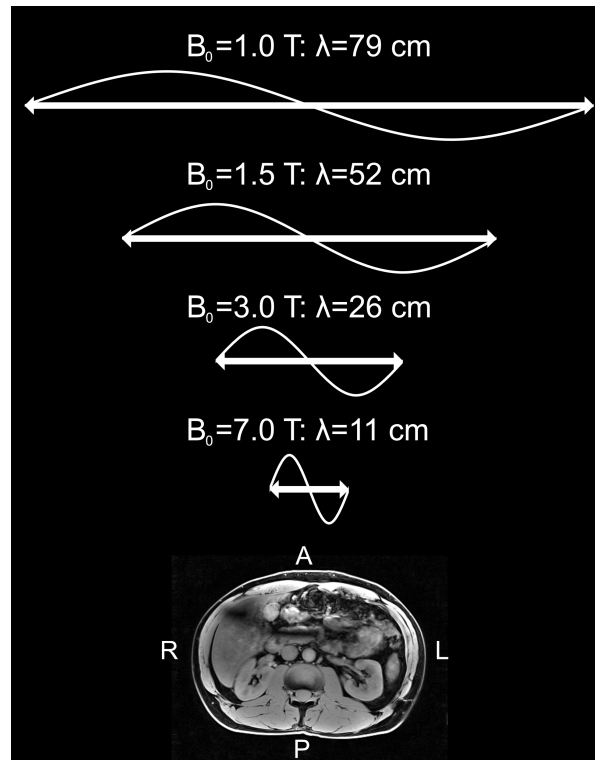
RF wavelength in tissue for different field strengths. For size comparison a *in-vivo* transversal MRI image is shown on the bottom.
